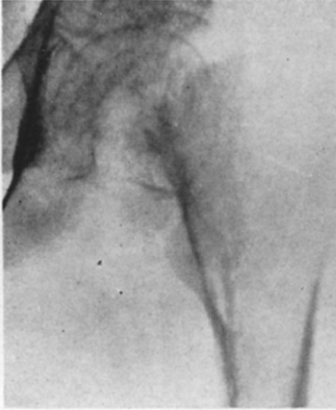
Case xix. Roentgenogram five months after accident; eleven weeks traction, eight weeks spica; no trace of union.
